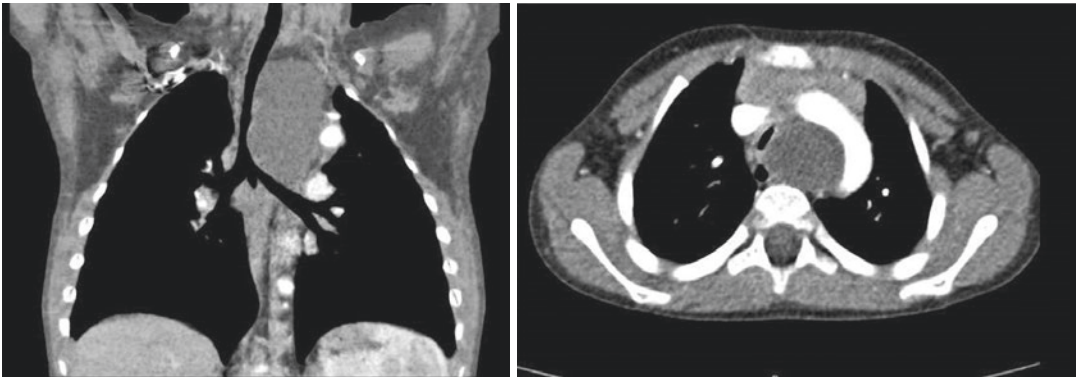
mediastinal cyst, corresponding to a foregut duplication cyst: coronal and axial CT scan
